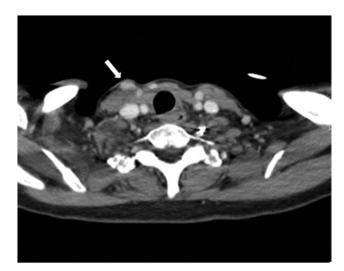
CT of the neck showing an ill-defined right neck mass at the level of to the lower right sternocleidomastoid muscle with represents the xanthogranuloma (arrow).
